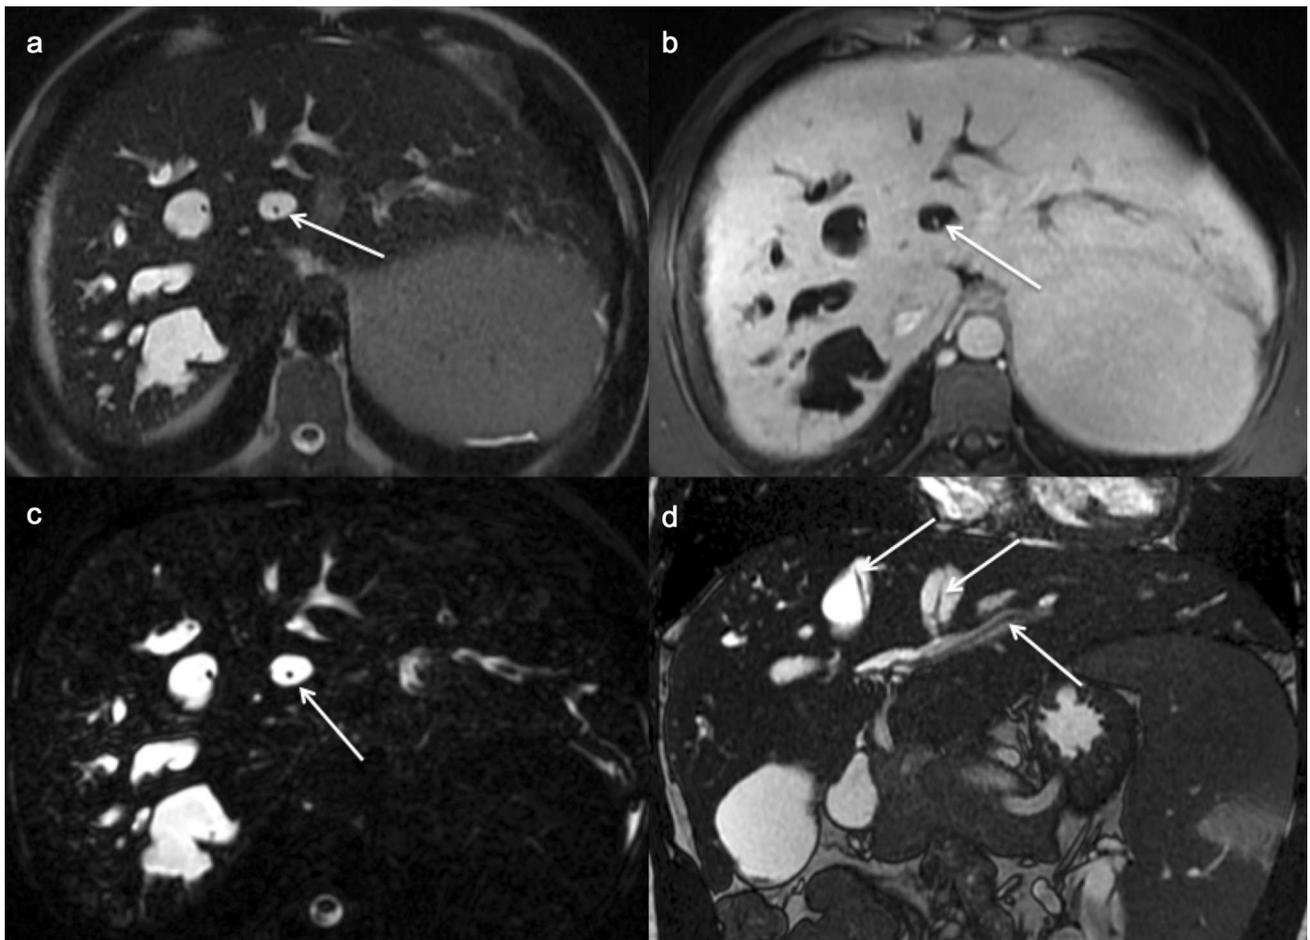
Caroli disease. MRI showing multiple saccular and tubular cystic dilations of the intrahepatic bile ducts on axial T2-w (a), axial contrast-enhanced T1-w (b), axial MRCP (c) and coronal MRCP (d) images. Notice the “central dot sign” (white arrows) inside the cysts
